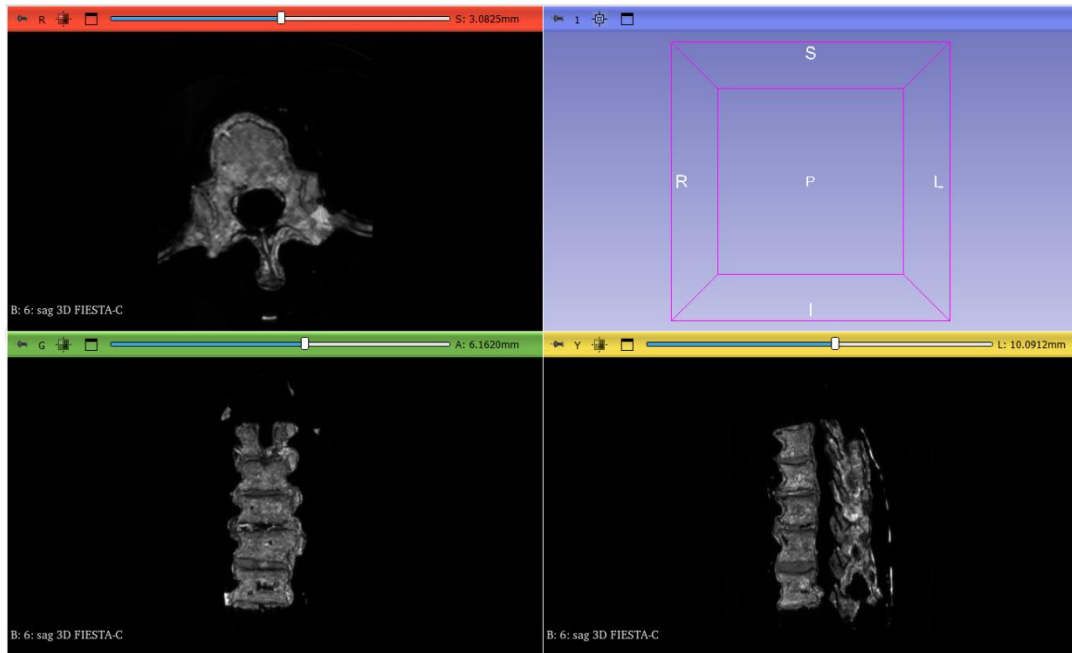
Importing MRI images into the 3D Slicer environment
